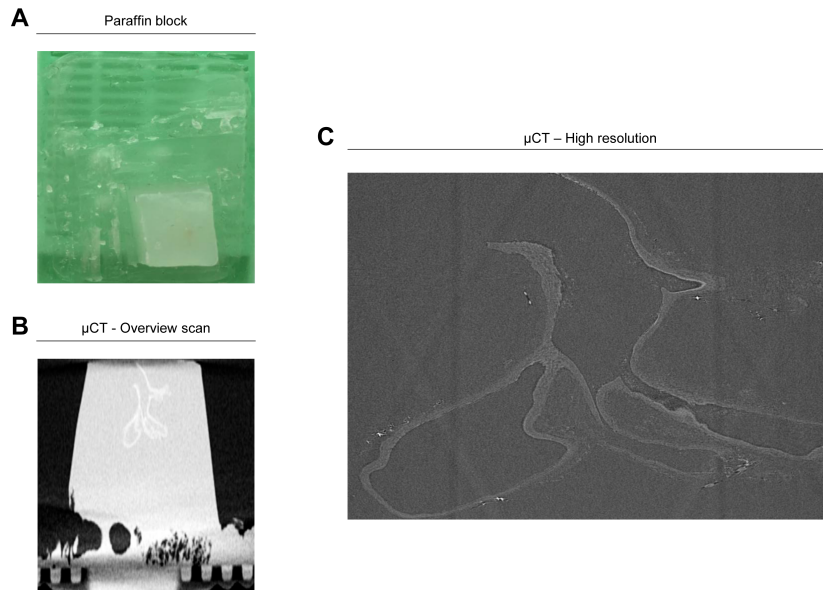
μ CT of aortic arch in paraffin. (A) Excessive paraffin was removed to reduce scan time. (B) Overview scan of aorta in paraffin. (C) High resolution scan of aortic arch in paraffin.
